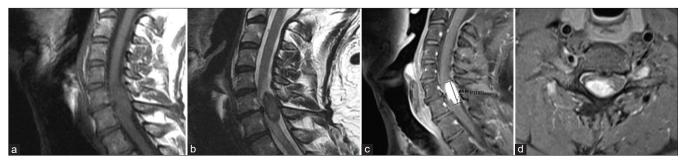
(a-d) Preoperative MRI aspect of the lesion, showing isointensity in T1 (a), hypointensity in T2 (b) and a homogeneous contrast enhancement lesion (c and d).
